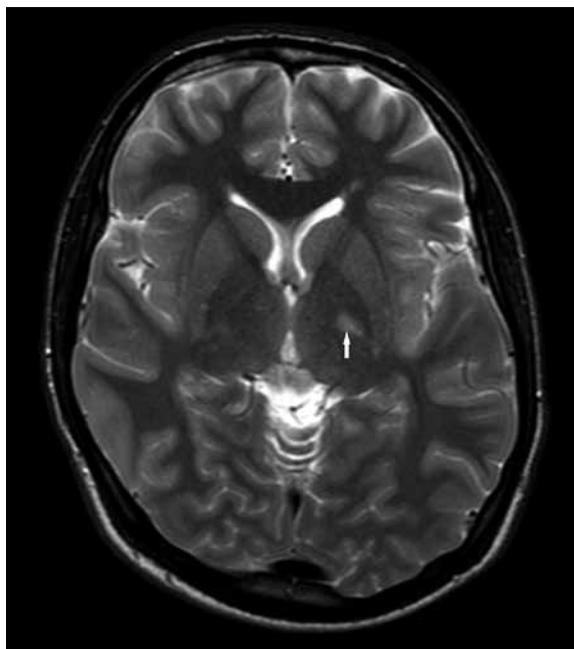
An 11-year-old boy, MRI brain scan, T2-weighted FSE sequence image, transverse plane – a demyelinating lesion in the front left thalamus (arrow).
